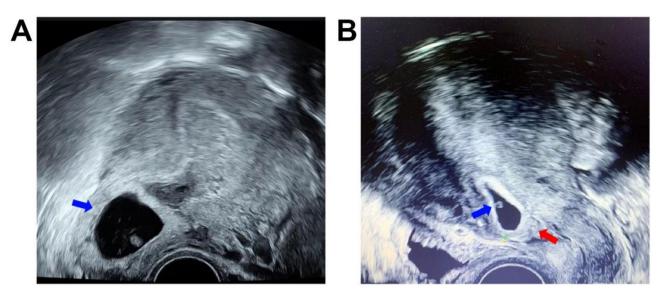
Ultrasound images of pregnancies in clinical subjects. A. Uterus of a woman with a normal pregnancy, with the gestational sac indicated by a blue arrow. B. Uterus of a woman with CSP, with the gestational sac indicated by a blue arrow and the scar from the previous cesarean section indicated by a red arrow
